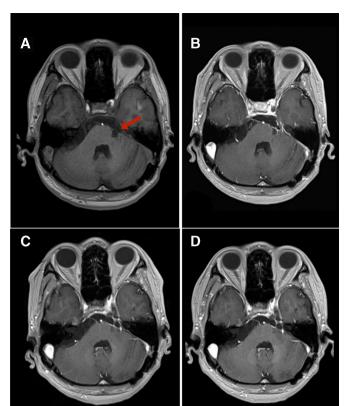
Post-treatment gadolinium-enhanced T1-weighted MRI showing the healing timeline of the CPA tumour. (A) 4 months after treatment. (B) 7 months after treatment. (C) 13 months after treatment. (D) 24 months after treatment. CPA, cerebellopontine angle.
